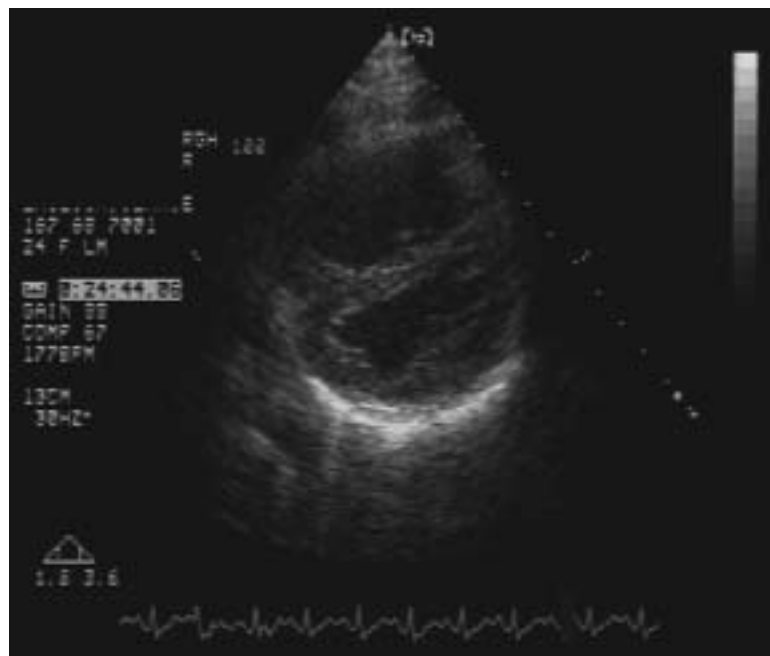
Parasternal short-axis view at peak exercise, showing a D-shaped LV, indicative of the high pressure in the RV.
